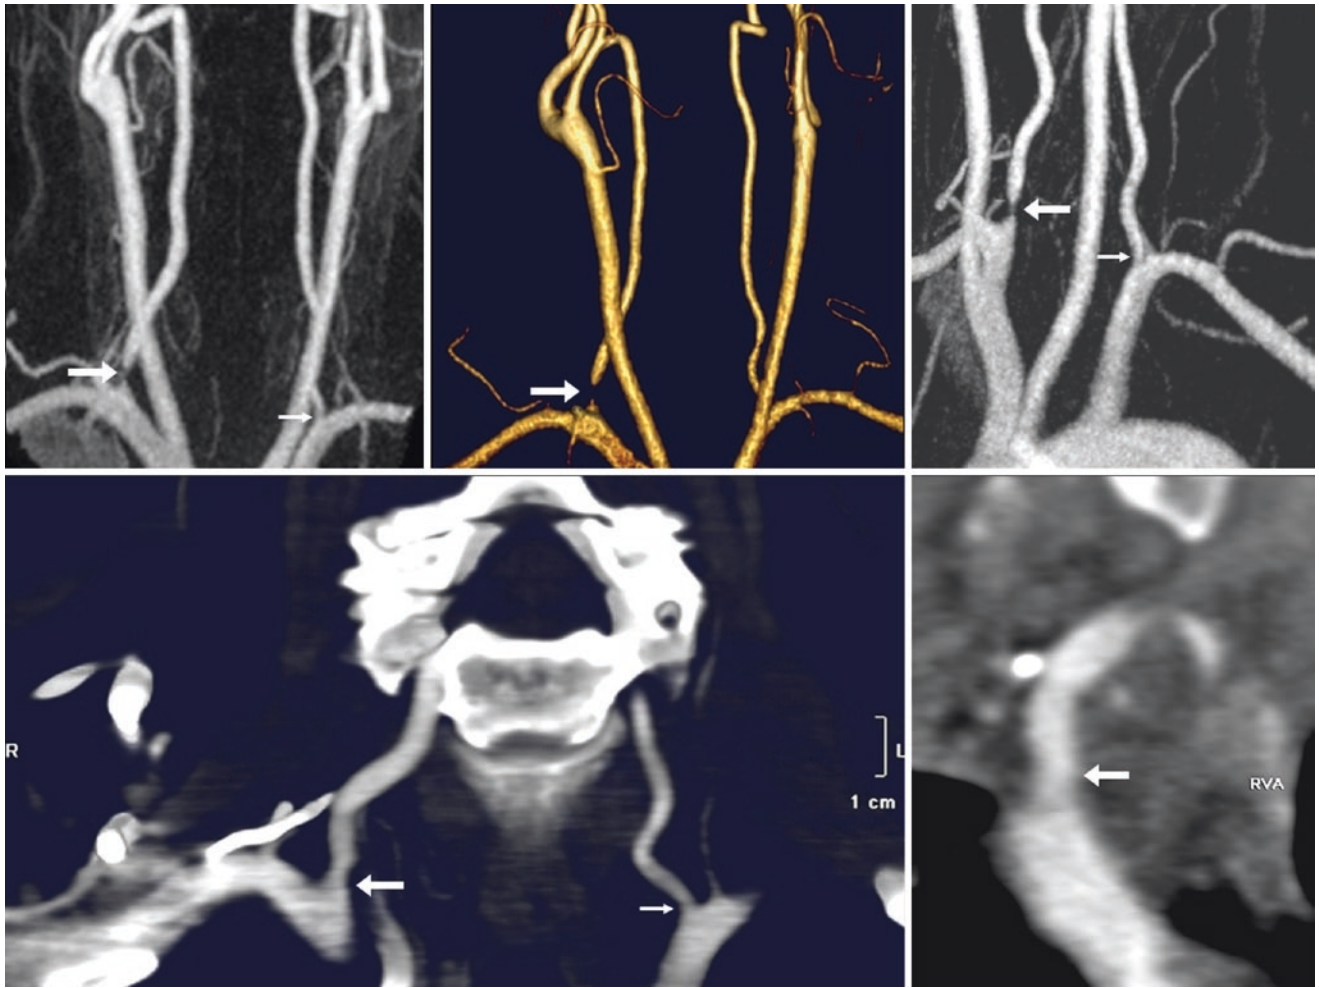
Pseudo-stenosis *top row*: in this 55-year-old, a right VA origin stenosis (*arrows*) was questioned on CEMRA MIP (*left*) and on high-resolution 3D VR (*middle*) AP views, as well as on an LAO view (*right*). *Bottom row*: CTA with coronal 4.5 mm (*left*) and magnified
